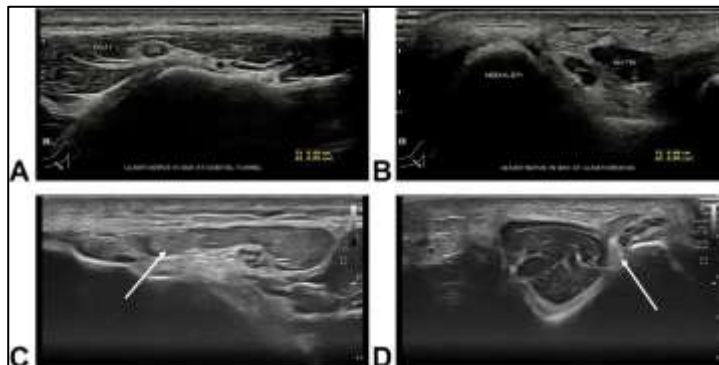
Ultrasonography to diagnose *cubital tunnel syndrome (CuTS)*. A The ulnar nerve (UN) is located between the 2 flexor carpi ulnaris (FCU) muscles. B The ulnar nerve around the elbow in the ulnar groove between the medial epicondyle (MEDIAL EPI) of the humerus and the medial head of the triceps (MH-TRI). C. The ulnar nerve (arrow) in a patient with CuTS in the flexor carpi ulnaris. D. The ulnar nerve (arrow) in a patient with CuTS in the FCU and perched on the medial epicondyle. The morphology of the nerve is abnormally hypoechoic and has lost its normal fascicular echo pattern.⁹
